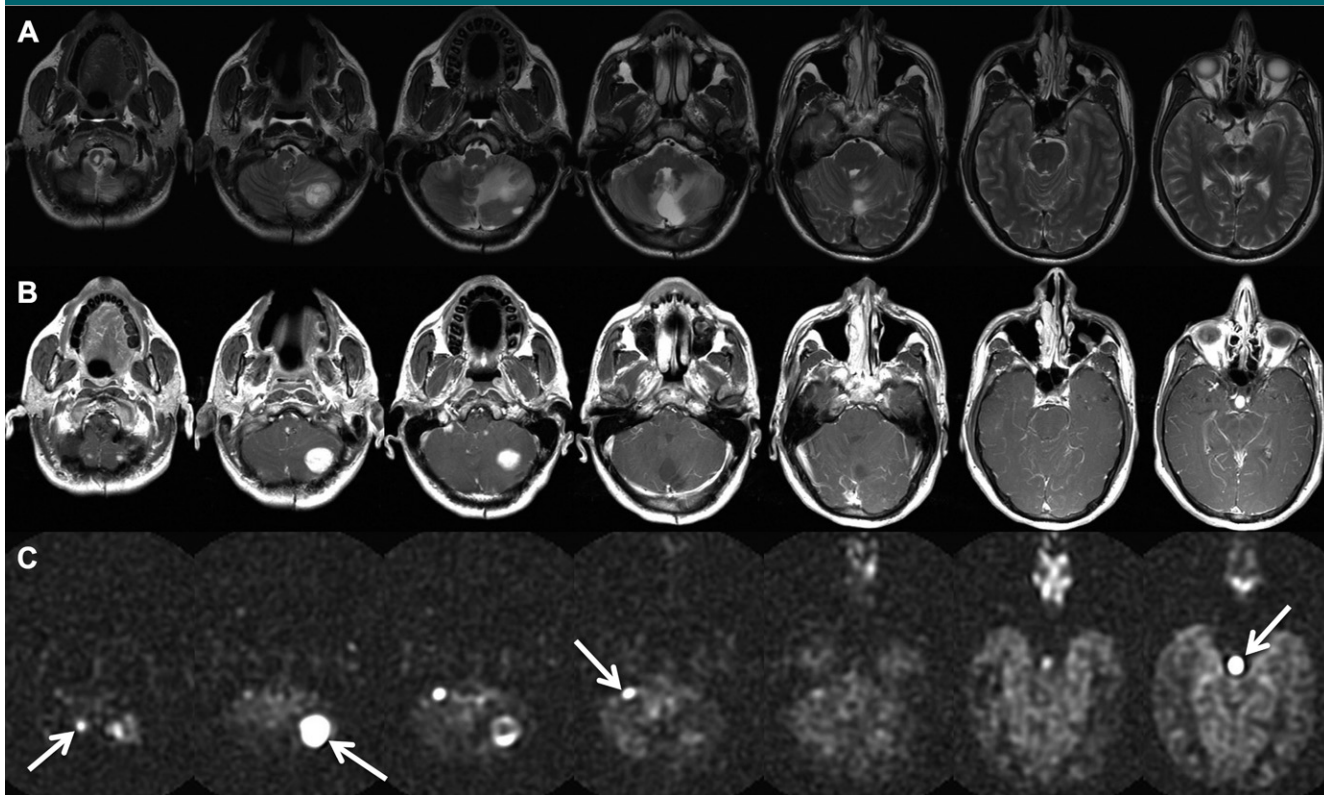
A, T2-weighted, B, postcontrast T1-weighted, and C, ASL images in a 40-year-old man with von Hippel Lindau disease and multiple hemangioblastomas after multiple prior surgeries. Arrows point to the extremely high CBF measured with ASL even in very small lesions.
